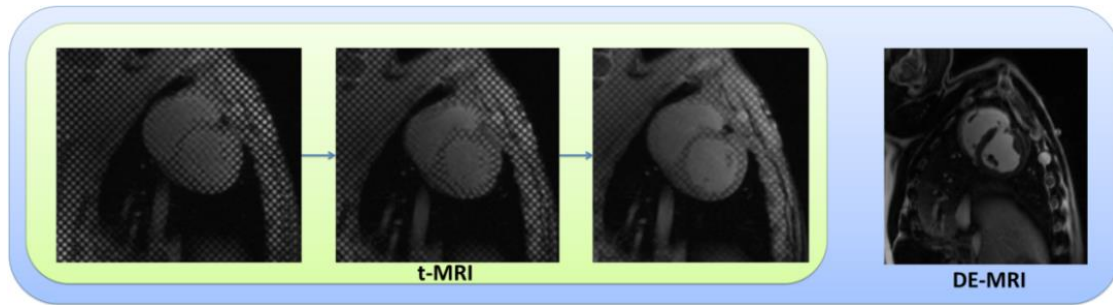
Registration validation using t-MRI and DE-MRI images.
